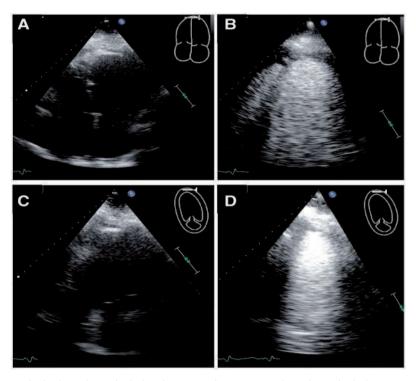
Standard echocardiography (SE) and corresponding contrast echocardiography (CE) images in a patient with advanced heart failure and a HeartMate 3 LVAD. SE resulted in a poor visualization of the LV, in both 4-chamber (A) and 2 chamber (C) apical views. After intravenous administration of the ultrasound contrast agent, CE yielded an improved visualization of the LV endocardial borders, in both 4-chamber (B) and 2 chamber (D) apical views. Videos of this example are available online.
